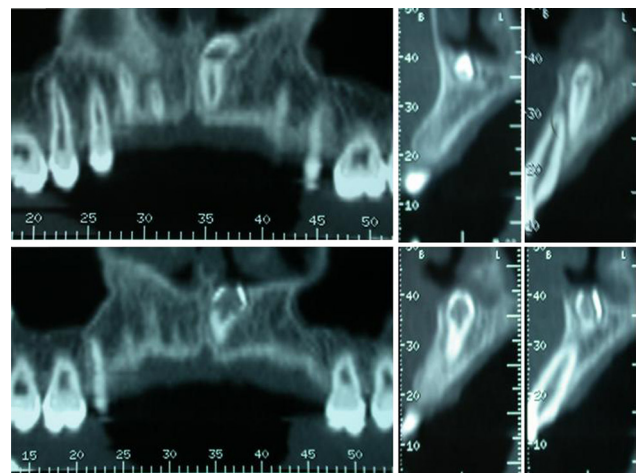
Computed tomography of the premaxilla showing a partially erupted tooth in the floor of the left nose.
